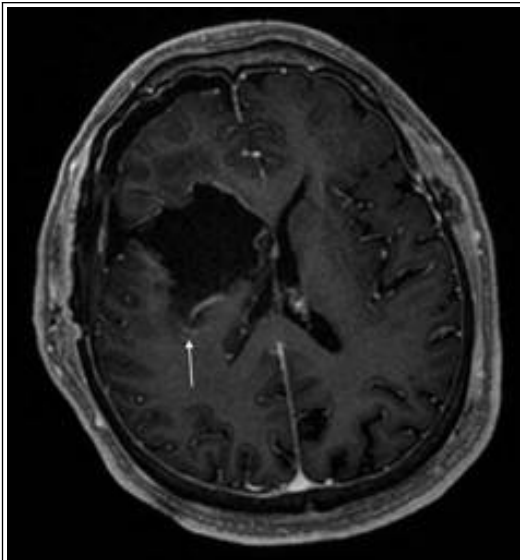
Post operative T1 contrasted MRI. Improved resection, small residual (arrow) where resection was minimized because of proximity to motor cortex
